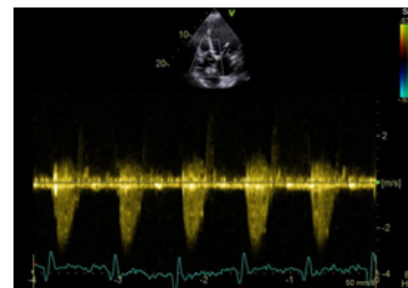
Doppler-echocardiography. Aortic mean gradient (23mmHg) indicative of light-mild stenosis.
